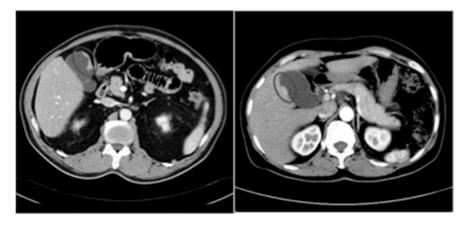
CT scan of peritoneal side (left) and liver side (right) gallbladder cancer. Reprinted with permission from *Gut and liver*¹⁴⁷.
